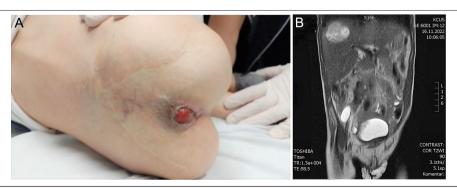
(A) A gross appearance of the immature teratoma recurrence (patient#7), 30 months following the surgery; (B) A pelvic and abdominal MRI scan (1.5 T) confirmed a 10×7×5 cm pelvic mass, infiltrating the surrounding structures, including the spinal canal, sacral, and vertebral-body structures. Extrapelvic propagation into soft tissue structures was also present. Multiple liver metastases, the largest measuring 4 cm, were also observed. MRI, magnetic resonance imaging.
